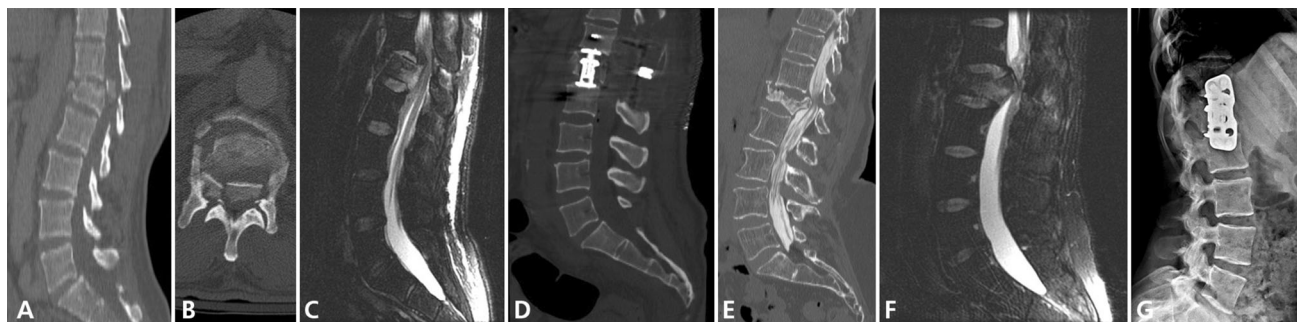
a Sagittal CT scan demonstrating L1 burst fracture with kyphotic deformity. b Axial CT scan demonstrating significant retropulsion of fractured vertebral body. c Sagittal T2 MRI demonstrating kyphotic injury and associated significant ligamentous injury. d Postoperative lateral radiograph demonstrating corpectomy, cage placement and correction of kyphotic deformity. e Sagittal CT
